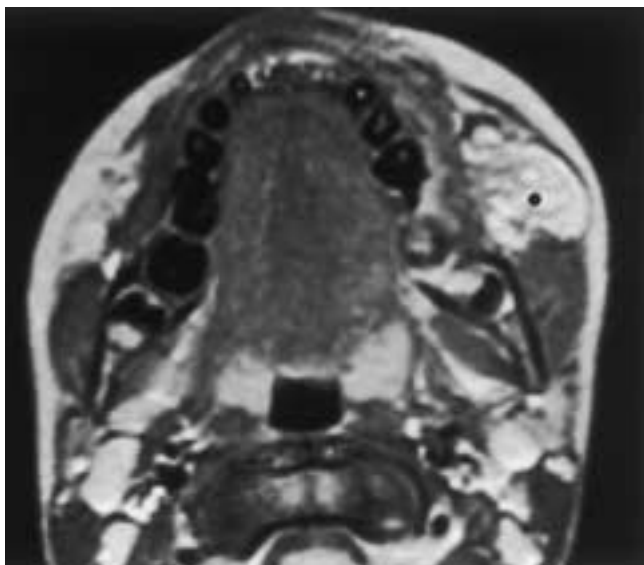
Venous malformation. Proton density MR image demonstrates a discrete, mildly heterogeneous, high signal intensity mass (dot) within the left buccal space immediately anterior to the left masseter muscle.
